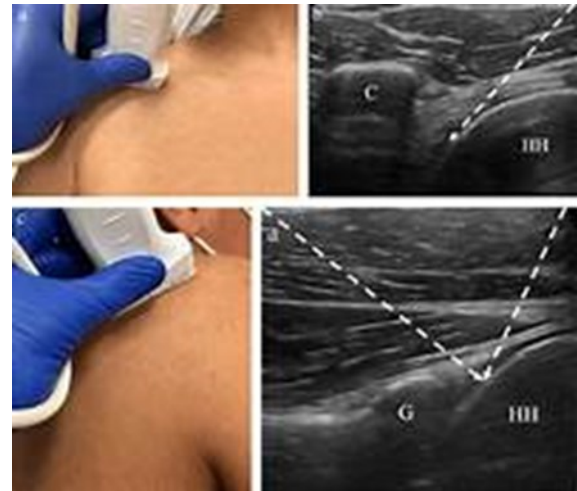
Ultrasound-Guided Glenohumeral Joint Injection. The image shows the needle trajectory during an ultrasound-guided injection into the glenohumeral joint, enhancing accuracy in delivering therapeutic agents.
